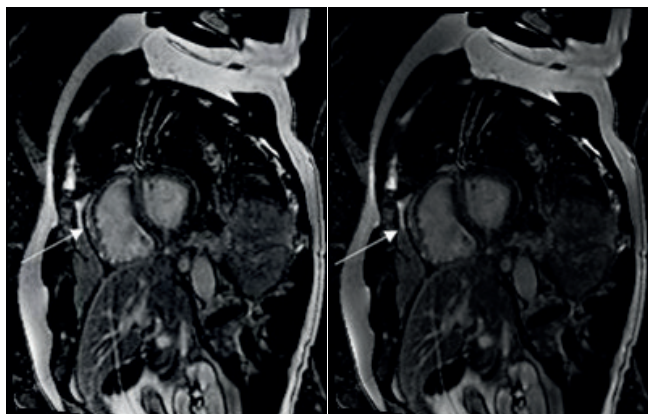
Cardiac MRI images showing late gadolinium enhancement (LGE) seen throughout the right ventricular (RV) free wall (arrow)
